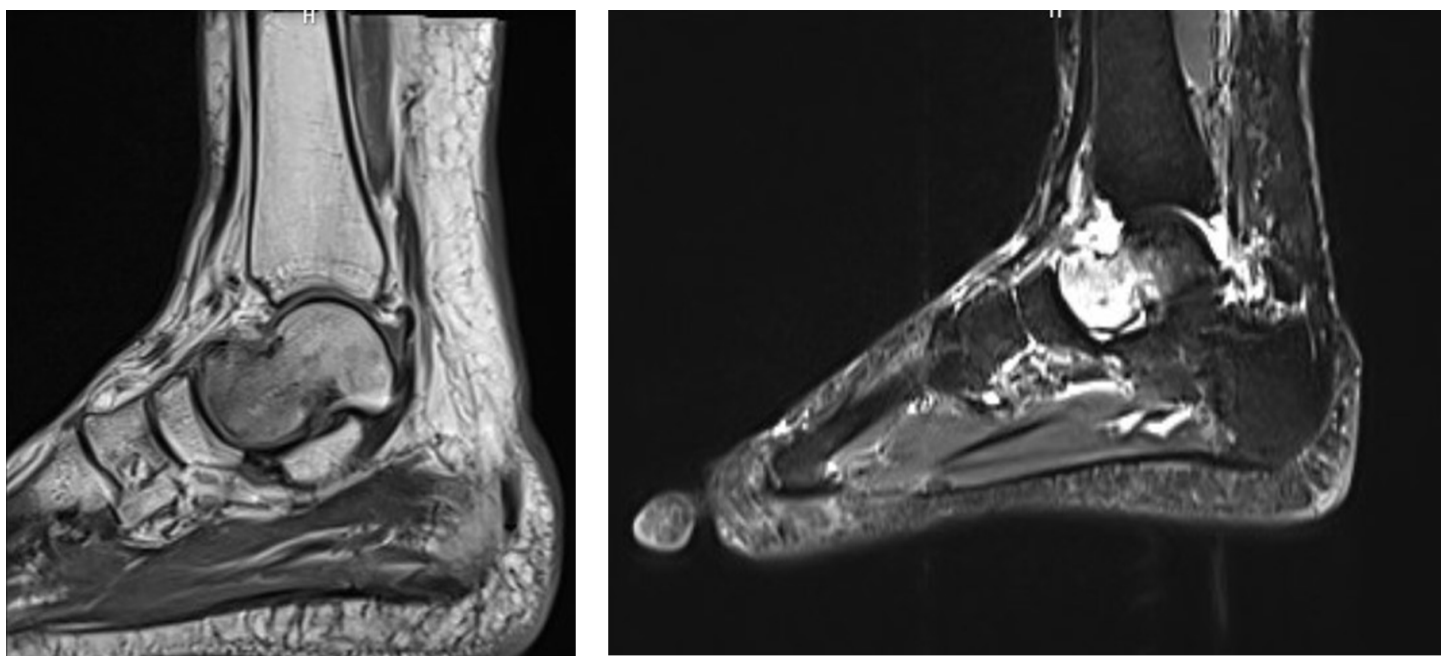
Sagittal T1 W MRI image showing low signal intensity and sagittal PDFS image showing high signal intensity in talar head and neck suggestive of marrow edema.
